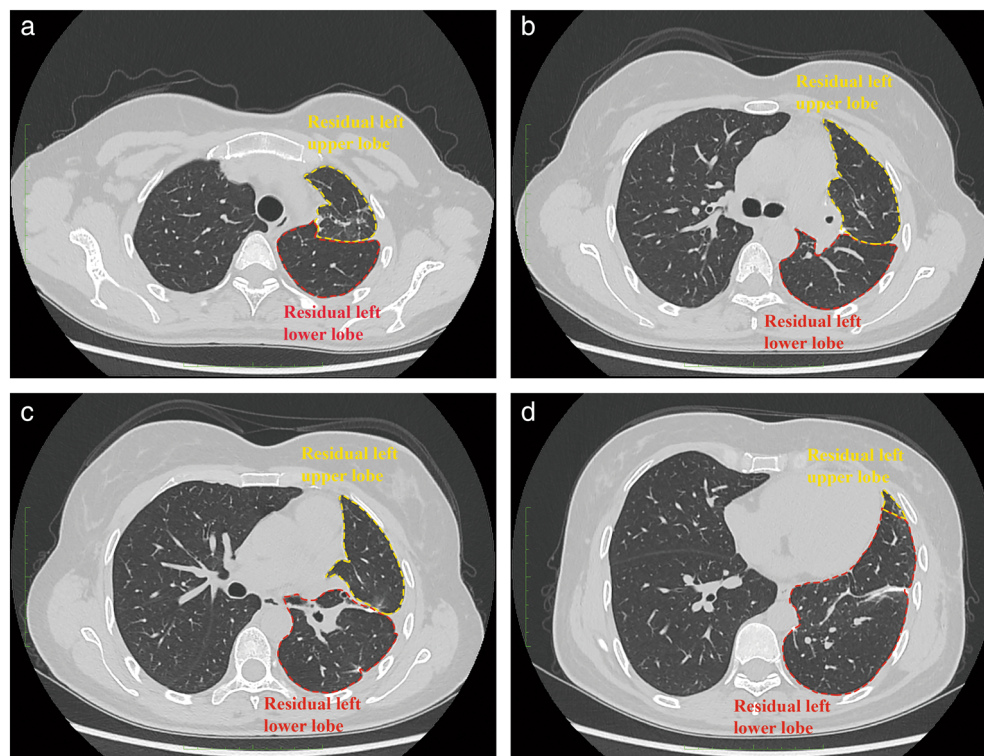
Chest high-resolution computed tomography (CT) scan 3 months after surgery which showed that the patient's left lung was well preserved with no nodule remnant, and that the residual left lung had expanded well.
